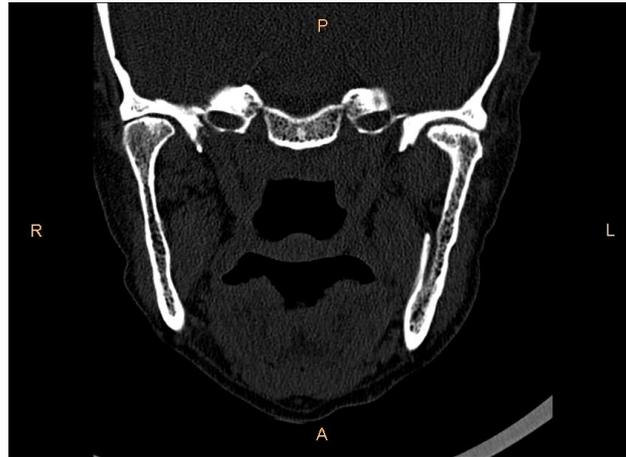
CT image(Coronal section)for rheumatoid patient explain narrowing with condylar space (Marjan Teaching Hospital in Al-Hilla City) .
